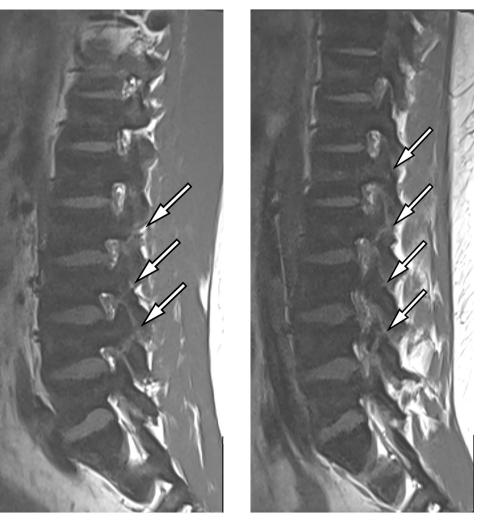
T1 weighted MRI images of the lumbar spine at left (A) and right (B) off midline sagittal images shows bilateral pars defects (arrows) at multiple levels of the lumbar spine.
